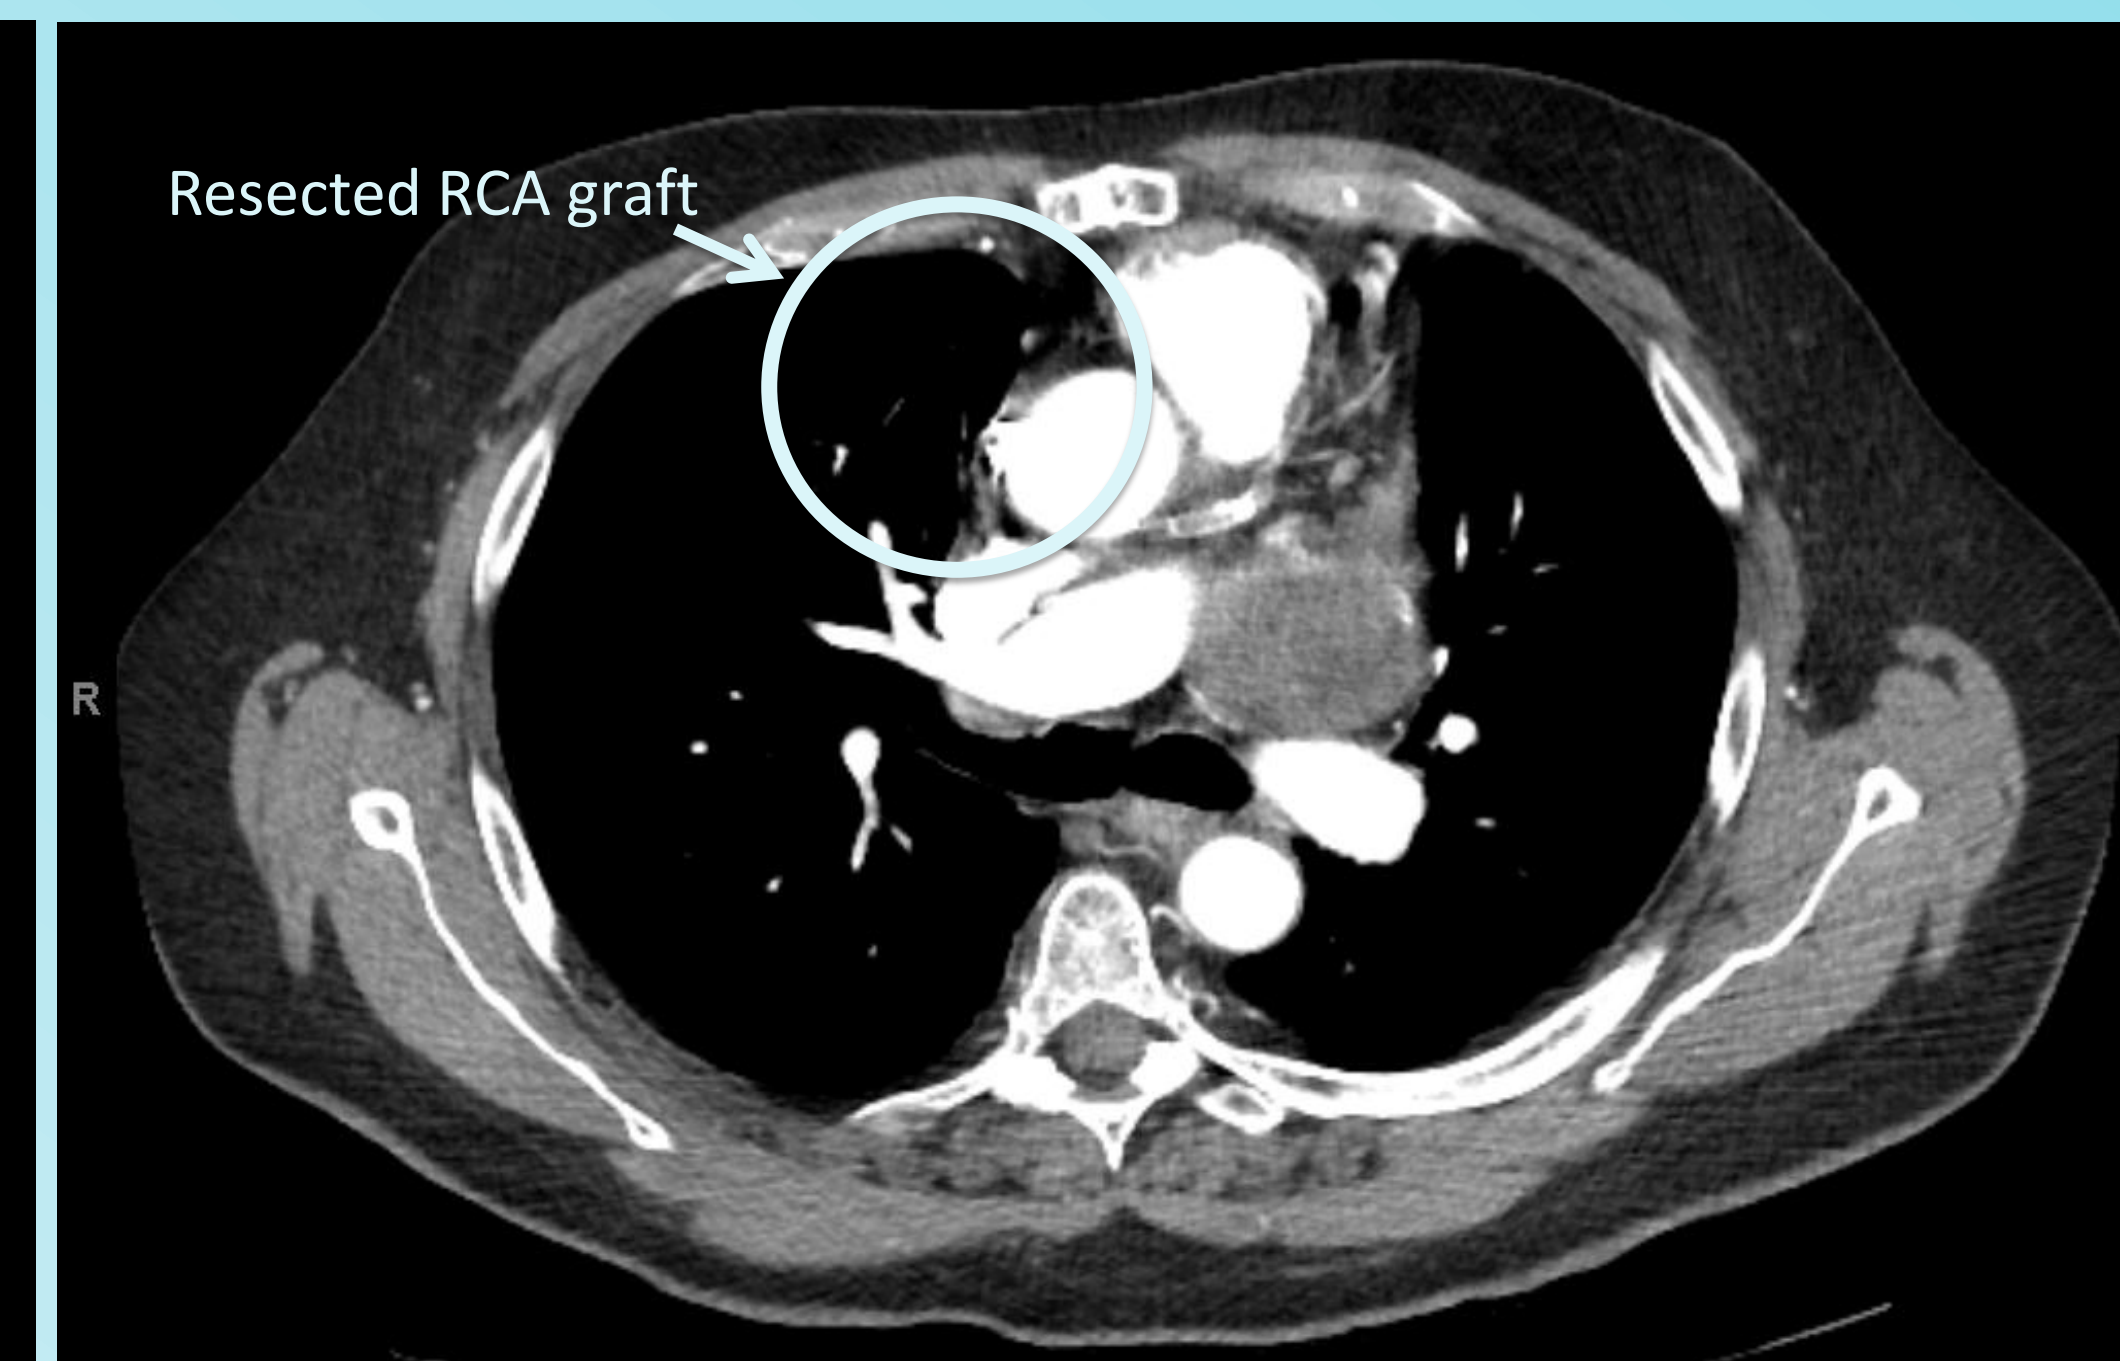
Patient CT scan following surgery showing the removal of the 8 cm RCA graft aneurysm
